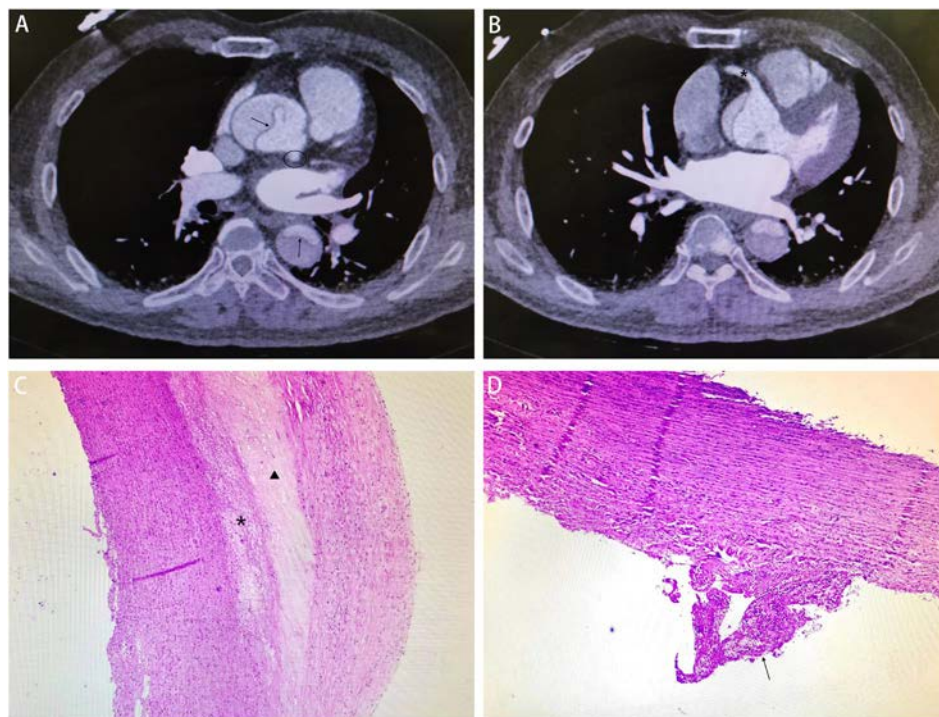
(A) The Aortic CTA. The black arrow shows the intima flap of the ascending and descending aorta and the black circle shows the left main coronary artery supplied by the true lumen. (B) The Aortic CTA. The black asterisk shows the right coronary artery supplied by the true lumen. (C) Aortic pathological examination. The black asterisk shows the foam cells and the black triangle shows the dissection. (D) Aortic pathological examination. The black arrow shows the thrombus.
